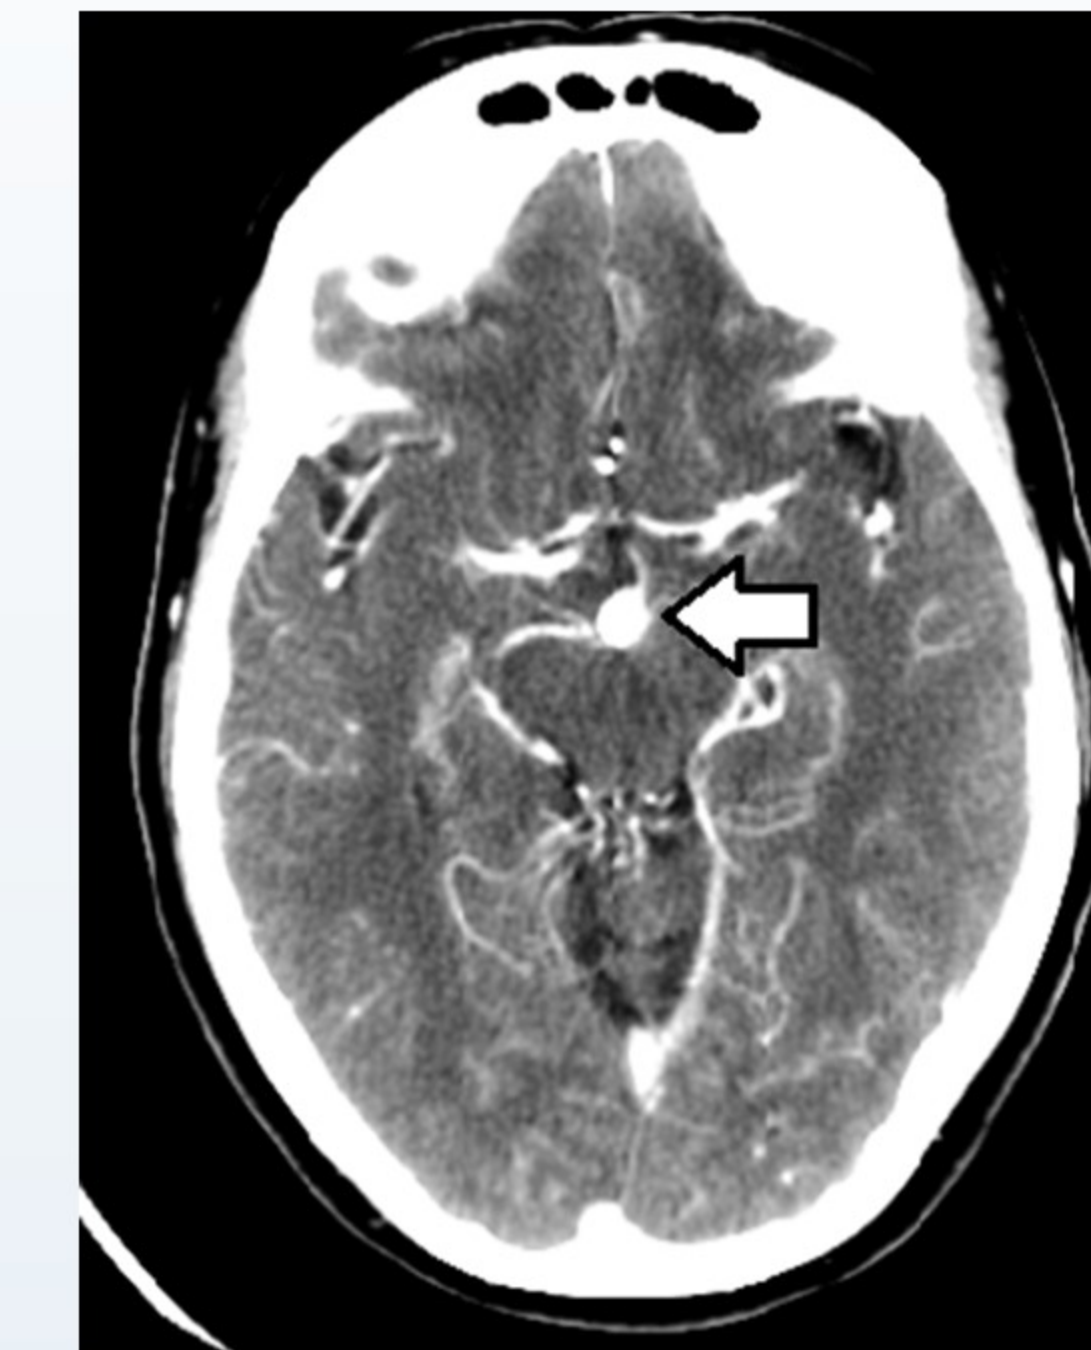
CT scan highlighting a 9x8mm basilar artery aneurysm (white arrow)
